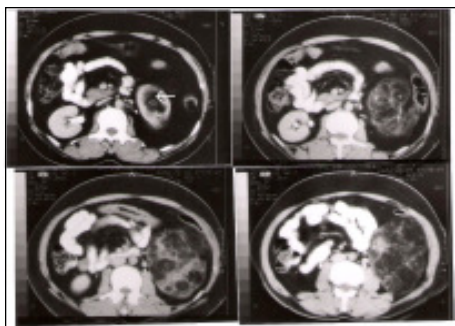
Contrast CT Showing Large Tumor Arising from Lower Pole of Left Kidney
